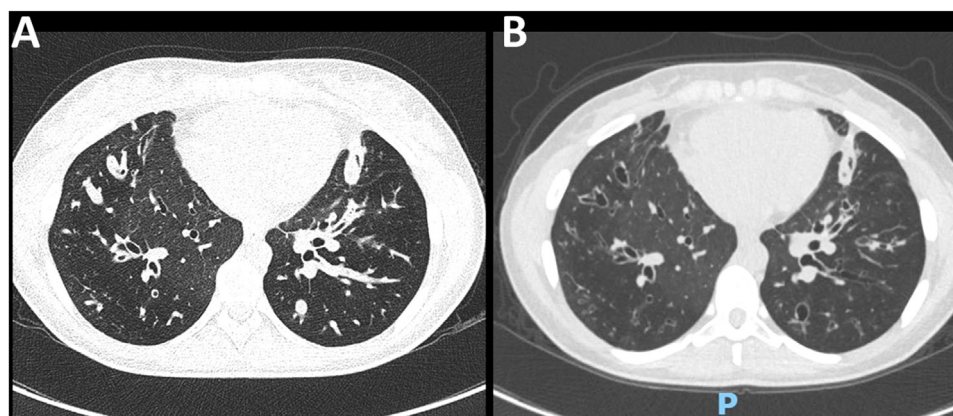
Chest CT scan of a 22-year-old female with CF (F508del/F508del genotype). (A) At baseline, diffuse bronchial thickening, intrabronchial mucus plugging, and bilateral bronchiectasis in lower lobes were evidenced. (B) After 6 months of ETI therapy, there was a significant reduction in mucus plugging and bronchial thickening.
